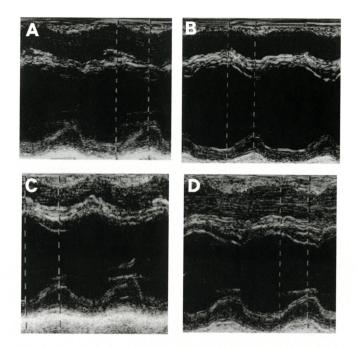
Transthoracic echocardiogram performed (A) just before the beginning of the administration of trastuzumab (LVDd, 45 mm; LVDs, 27 mm; LVEF, 70%; FS, 40%), (B) 10 weeks after the administration of trastuzumab (LVDd, 49 mm; LVDs, 33 mm; LVEF, 61%; FS, 33%), (C) 2 weeks after discontinuation of the administration of trastuzumab (LVDd, 48 mm; LVDs, 31 mm; LVEF, 65%; FS, 36%), and (D) resumed use of trastuzumab, a week before her death (LVDd, 45 mm; LVDs, 29 mm; LVEF, 65%; FS, 36%). EF: ejection fraction, FS: fractional shortening, LVDd: left ventricular diastolic dimension, LVDs: left ventricular systolic dimension.
